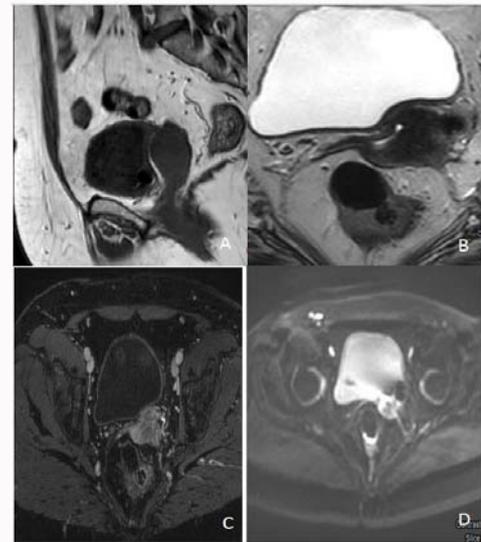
Pelvic magnetic resonance imaging examination. (A) Sagittal T1-weighted MRI. (B) Coronal T2-weighted MRI. (C) Axial mDIXON-W_HR MRI. (D) DWI. Enhancing mass lesion at the vaginal cuff, originating from the residual cervix and it measured about 3 cm × 3.4 cm × 3.6 cm in maximum diameters. Separate from the posterior wall of the urinary bladder, the mass shows significant water diffusion restriction on the DWI and ADC maps.
